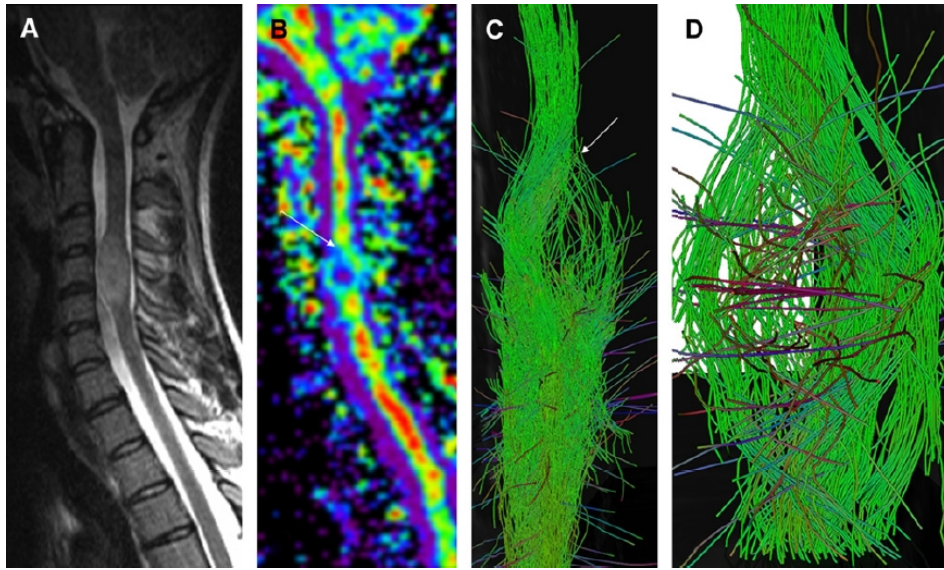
Cervical spinal cord astrocytoma. (A) Midsagittal T2-weighted image shows an expansile and mildly hyperintense tumor at the C2-C4 levels. (B) Directionality sagittal map shows loss of anisotropy in the mass (blue color, arrow) that is focal and compatible with diagnosis of WHO grade II astrocytoma. Anisotropy is immediately reestablished along tumor margins due to the lack of edema. (C) FT map shows splaying of fibers by a tumor normalized at the tumor margin (arrow). (D) Magnified FT map shows fiber splaying by a tumor. Most fibers are intact due to the nondestructive nature of tumor.
